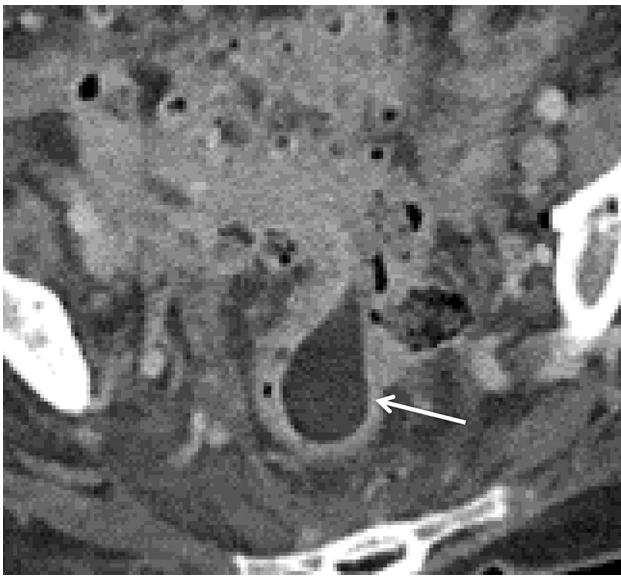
Rectal Lipoma. CT easily demonstrates the fatty nature of this smooth walled submucosal lipoma (arrow).
